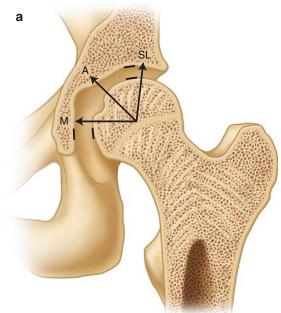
(a) Femoral head migration patterns, SL superolateral, A axial, M medial. (b) AP radiograph hip with superolateral migration femoral head with joint space loss most pronounced on the upper and outer aspect of the hip joint. (c) Axial migration occurs in line
